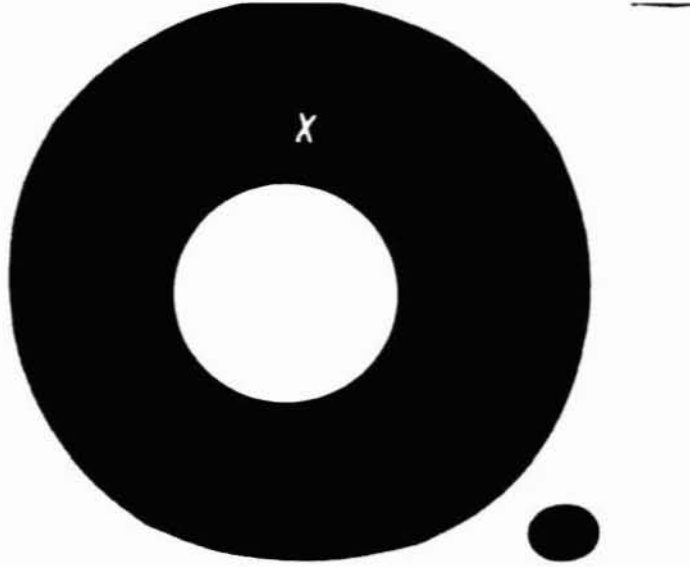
X-ray photographs of NR-150BS system (by using cone)
